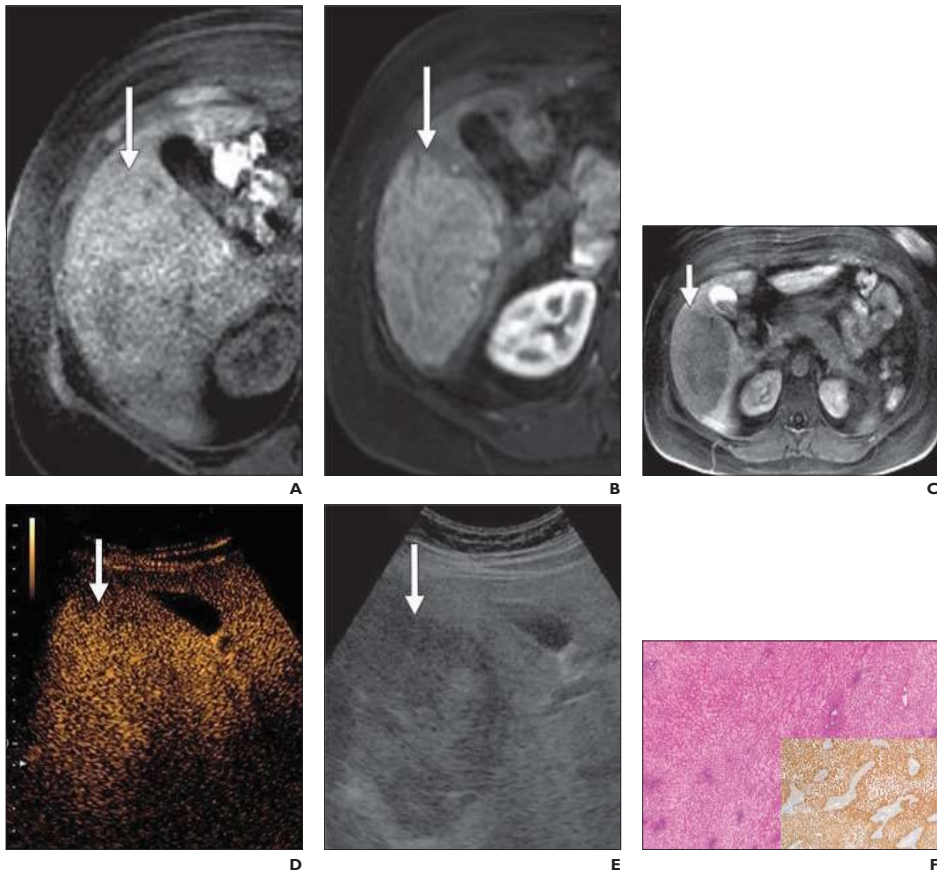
32-year-old woman with large focal liver lesions who underwent contrast-enhanced sonography and MRI performed with liver-specific contrast agent; findings were discordant for hepatocellular adenoma.
